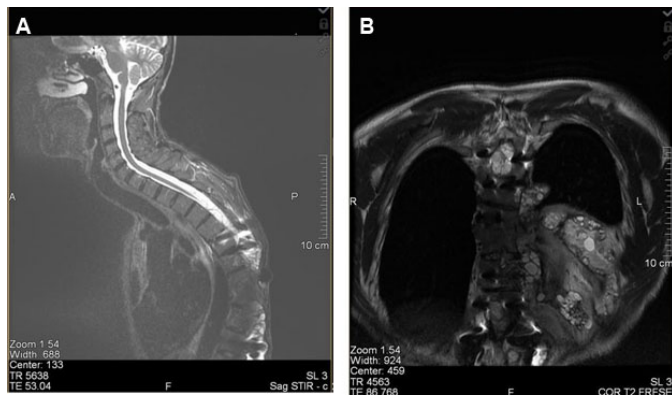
(A and B) MRI images from 15.12.2021. Septated cystic lesions can be observed starting from Th4 level continuing throughout the thoracic spine. Visualization is limited due to metallic implants. Extensive perifocal infiltration can be observed to the left of the spine at Th7 level on coronal plane infiltrating paravertebral soft tissue.
